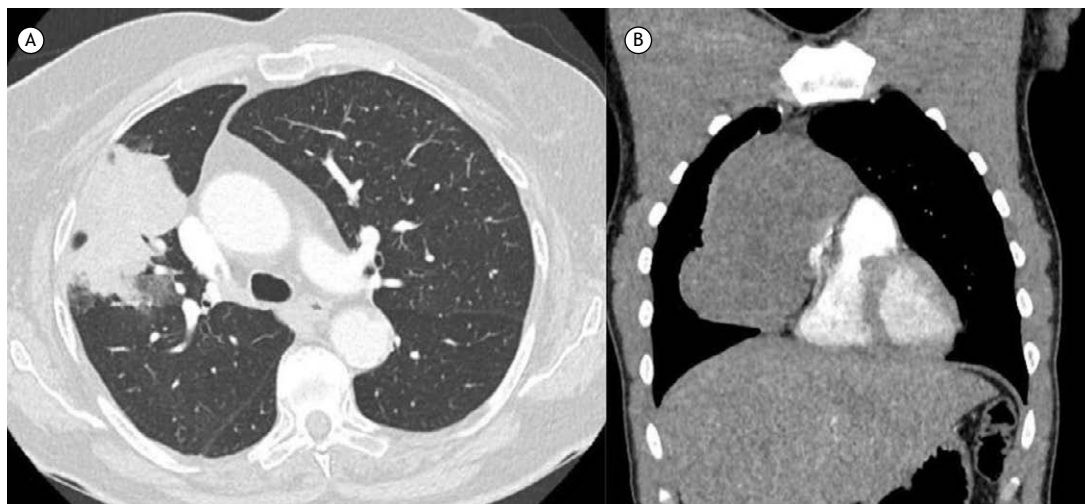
Axial CT scans with lung window settings. In A, a mass with lobulated contours in the anterior segment of the upper lobe of the right lung in a patient with lung adenocarcinoma. In B, an anterior mediastinal (prevascular) mass, with soft-tissue attenuation, in a patient with mediastinal seminoma.
